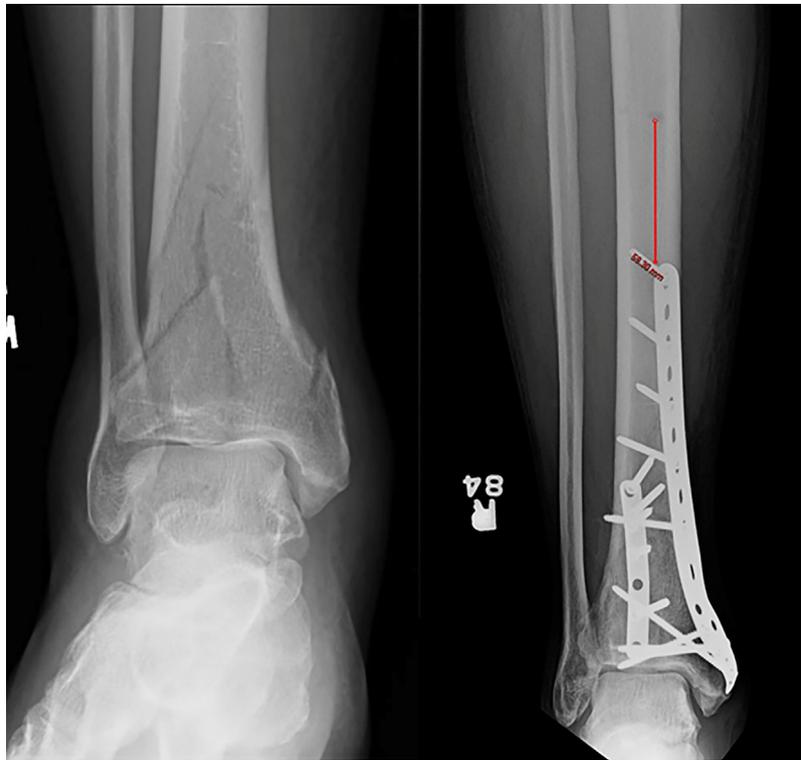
Anteroposterior radiographs from the initial injury (right) and after definitive fixation (left) of a distal tibia fracture. The measurement was made from the proximal aspect of the plate to the closest external fixator pin site.
